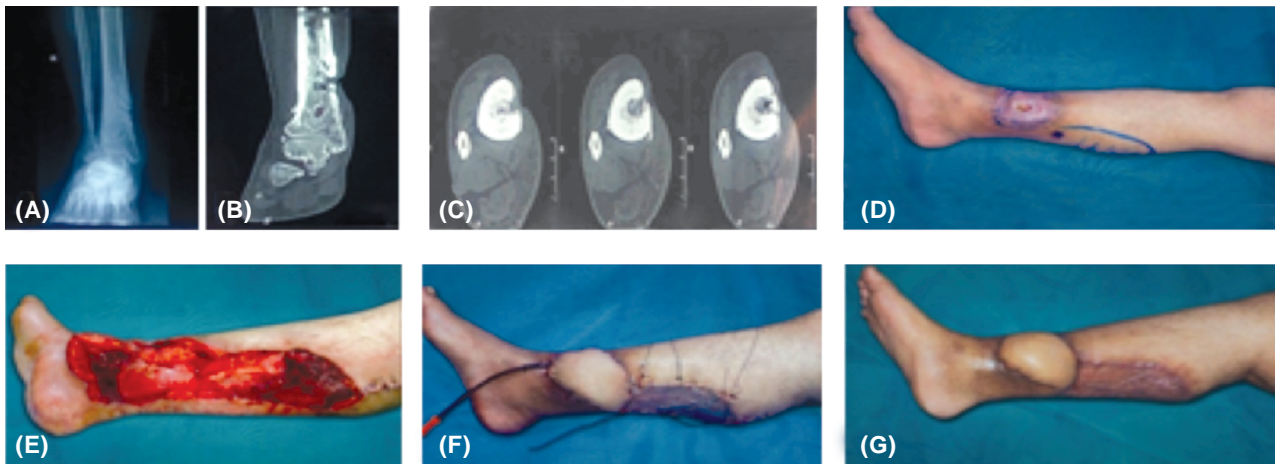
Myo-cutaneous Case; (A) X-ray, (B) Axial CT, (C) Coronal CT showing superficial osteomyelitis, sinus and bone erosion, (D) Defect and flap design, (E) Myo-cutaneous flap elevation (part from the medial gastrocnemius muscle), (F) Post-op defect coverage and donor site STSG, (G) Donor site showing partial loss, (H) Late follow-up showing complete healing with donor site homogeneity and relatively bulky flap.
